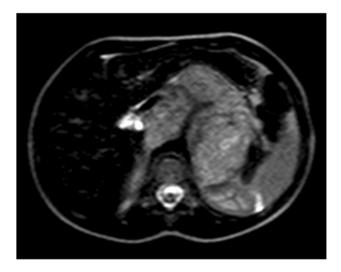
Axial MRI demonstrating vascular encasement by the neuroblastoma
